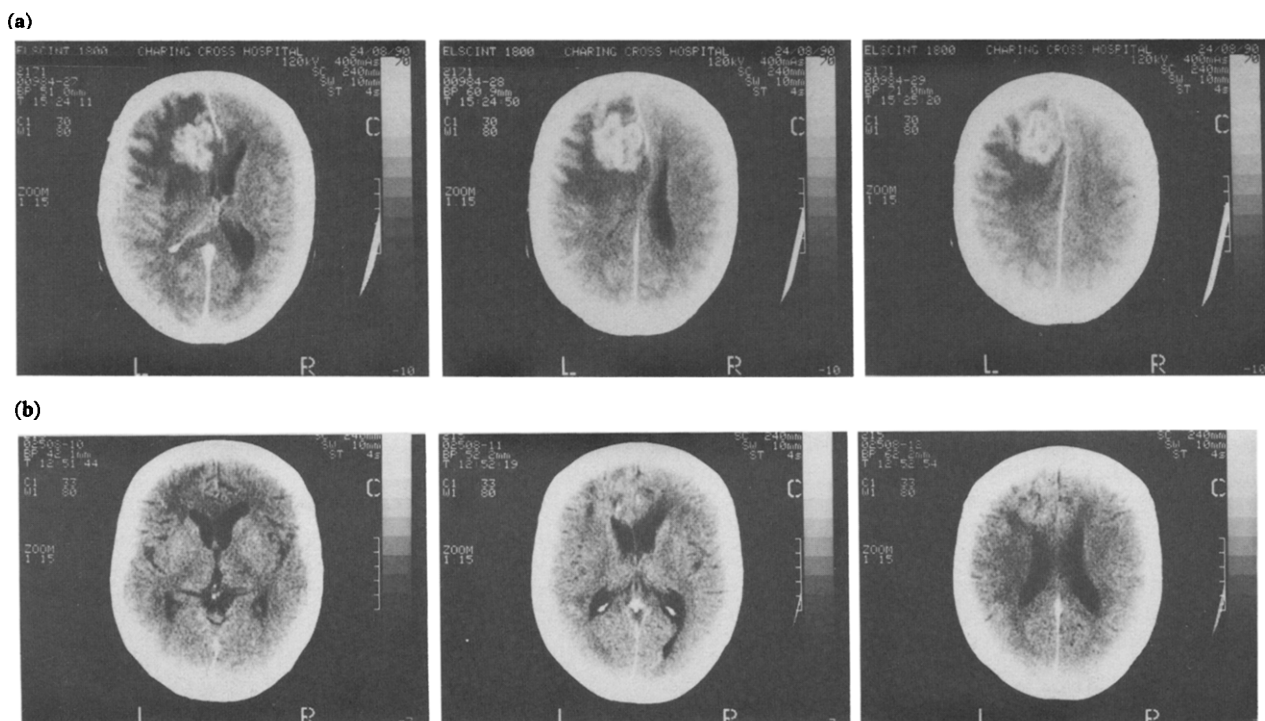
Pretreatment CT scan (a) and CT scan after six courses of temozolomide (b) of a patient with a grade 4 glioma which had recurred after radiotherapy. The marked improvement in CT scan was accompanied by complete resolution of symptoms.
